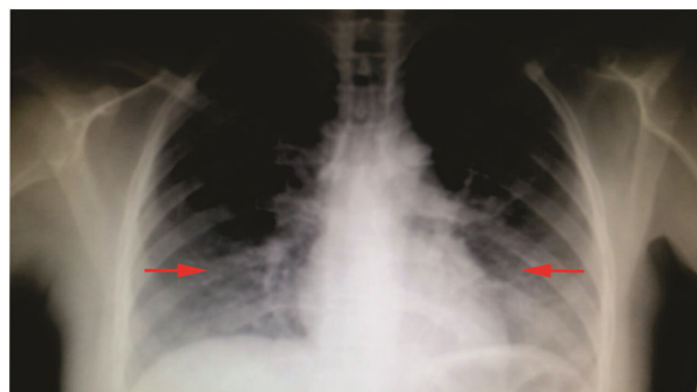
A chest X-ray showing bilateral interstitial pneumonia typical of *Pneumonia carinii pneumonia*.
